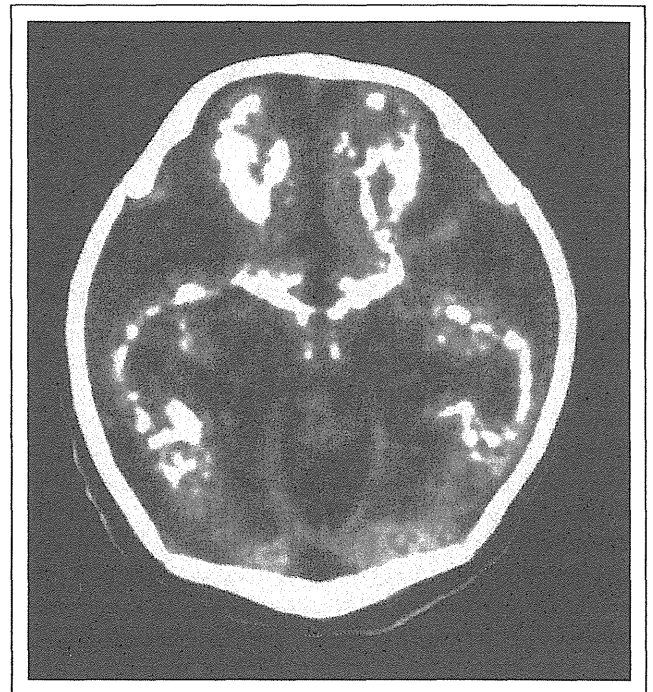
Computed tomographic scan of the head shows linear or patchy high signals consisting of calcifications within or immediately beneath the cortex and the enlargement of the lateral ventricles.
